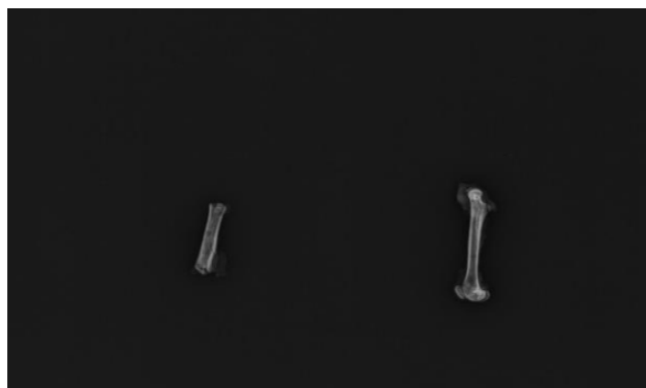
Radiograph showing Nebivolol treated femurs (n=14)
